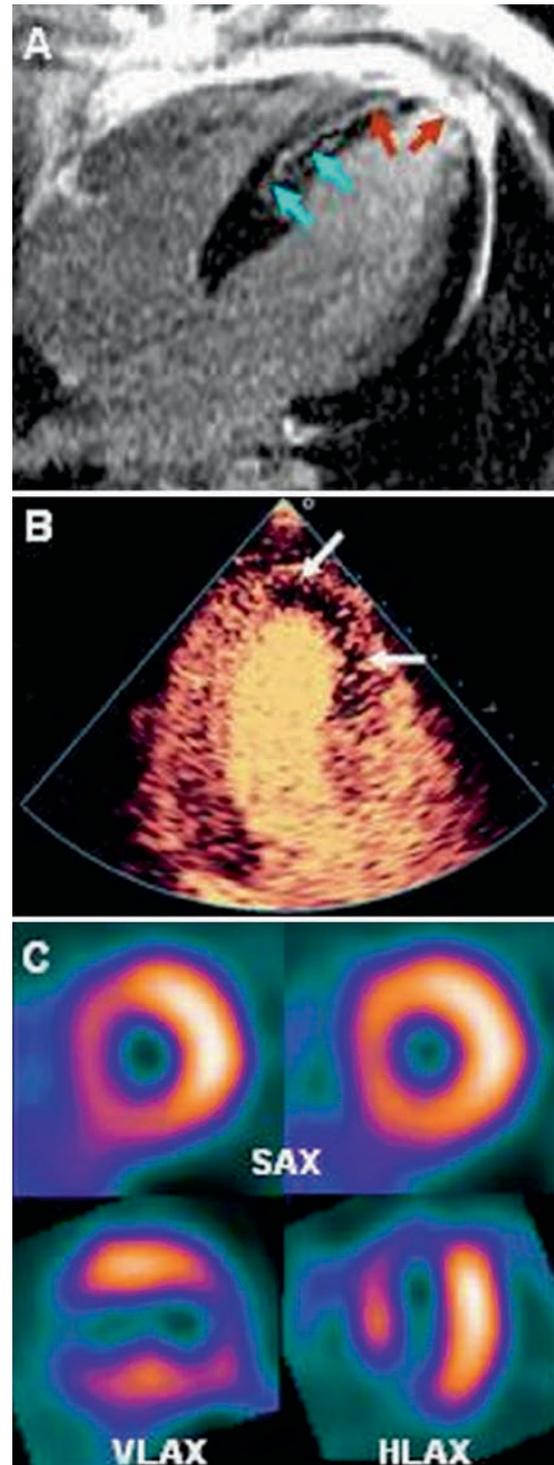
Images from a 62-year-old patient who presented with an anterior myocardial infarction. (a) CMR demonstrates a full thickness apical infarction (red arrows), which extends to the mid-septum with greater than 50% myocardial wall involvement again implying low likelihood of viability. (b) The MCE apical 3-chamber view demonstrates not only an absence of contrast uptake at the apex but also severely reduced opacification extending to the mid-septum. (c) Although the SPECT images clearly demonstrate an apical full-thickness infarction, they only show a mild reduction in tracer uptake in the septum as demonstrated in the mid-apical short-axis view implying $\leq 50\%$ TEI with significant viability in the infarct related territory
